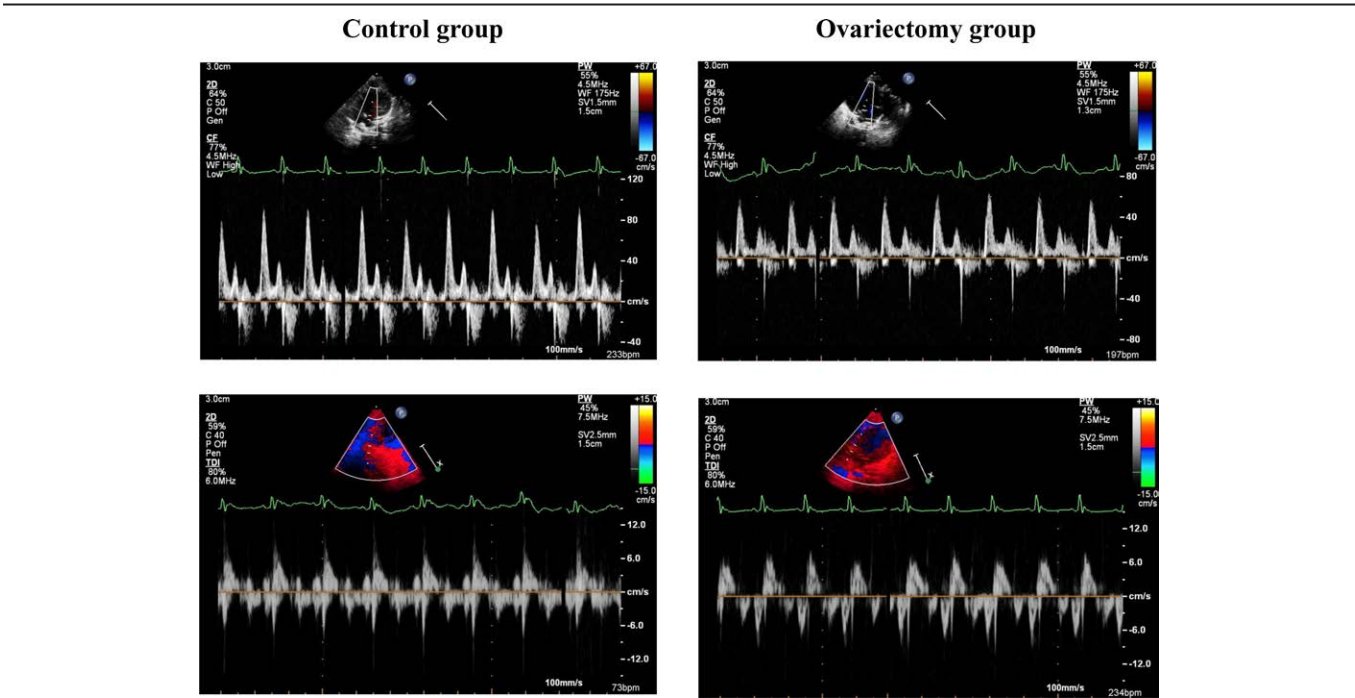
The echocardiographic image comparing parameters of cardiac structure and function between control and ovariectomy group. Left upper panel: mitral valve inflow velocity pattern in the control group. Left lower panel: tissue doppler of mitral annular velocity pattern in the control group. Right upper panel: mitral valve inflow velocity pattern in the ovariectomy group. Right lower panel: Tissue doppler of mitral annular velocity pattern in the ovariectomy group.
